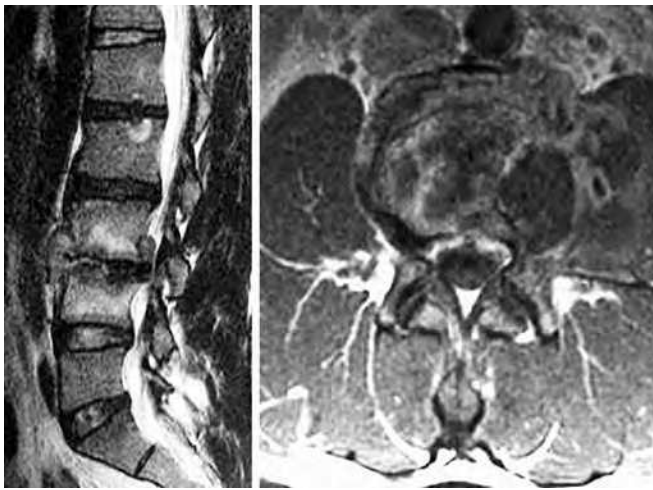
Sagittal and axial magnetic resonance imaging demonstrate paradiscal type of lumbar tuberculosis with damage to the vertebral endplates and extension of infection into the vertebral bodies.
